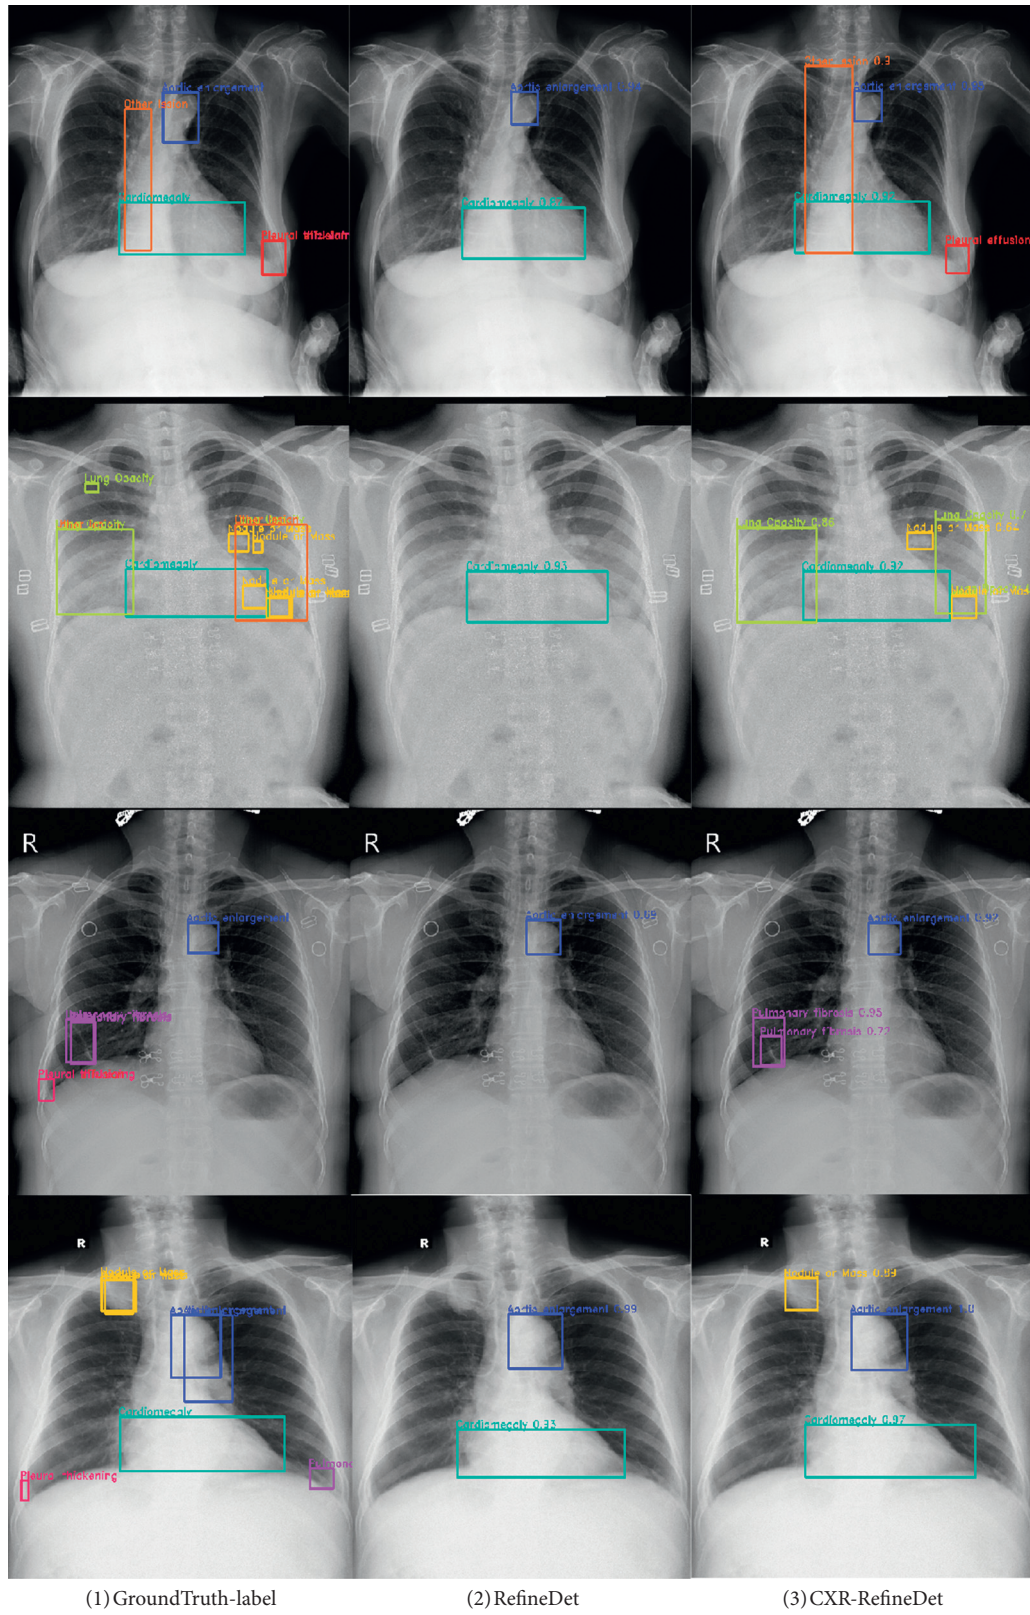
The chest X-ray test results, where (1) is the true label of the VinDr-CXR dataset, (2) and (3) are the comparison images of the test results of RefineDet and CXR-RefineDet on the VinDr-CXR test set, respectively, and the target boxes of the same color represent the same lesion category.
